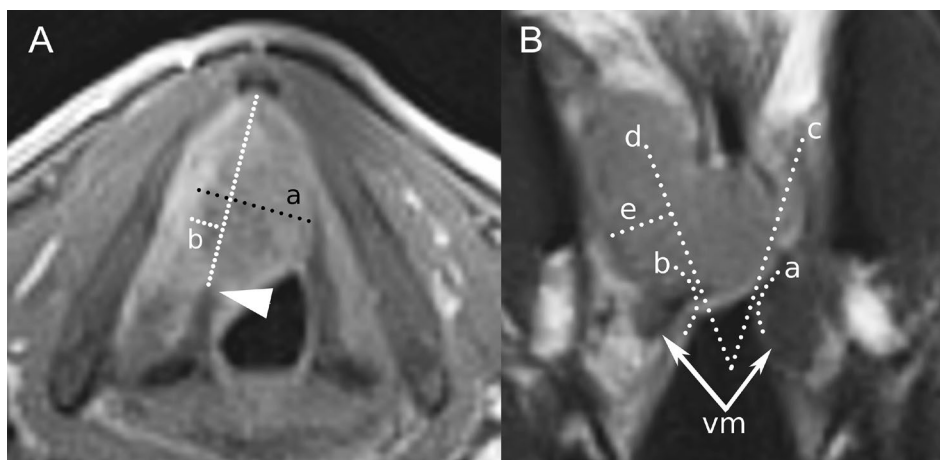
Examples of radiologic depth of invasion (rDOI) assessment on contrast-enhanced magnetic resonance. (A) Post-contrast T1-weighted axial image. Stepwise measurement of radiologic depth of invasion (rDOI): Draw a reference line from the vocal process of the arytenoid (arrowhead) to the anterior commissure, then project a perpendicular segment from this line to the deepest tumor margin; segment (b) corresponds to rDOI. Note the distinction between rDOI and maximum tumor thickness (a). (B) T2-weighted coronal image of the same patient. On the coronal plane, rDOI assessment may be more challenging because the curved anatomy and normal anatomic landmarks can be partially obscured by tumor. Stepwise measurement of rDOI: Identify the vocalis muscle and true vocal folds, and delineate their profiles on the healthy side (a) and the pathologic side (b); when the affected-side contour is indistinct, mirroring the contralateral healthy profile can be used as a pragmatic reference. Draw tangential lines (c, d) and then project a perpendicular segment from line (d) to the deepest tumor margin; segment (e) corresponds to rDOI.
